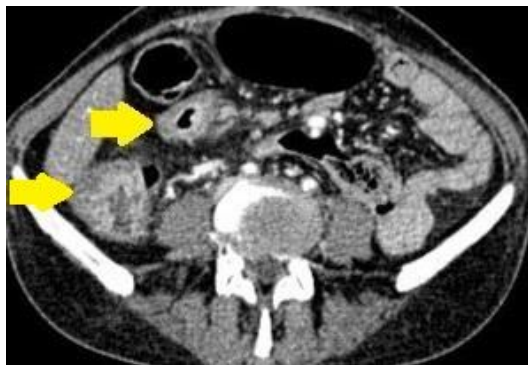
CT of the abdomen and pelvis showed ileocolic parietal thickening
